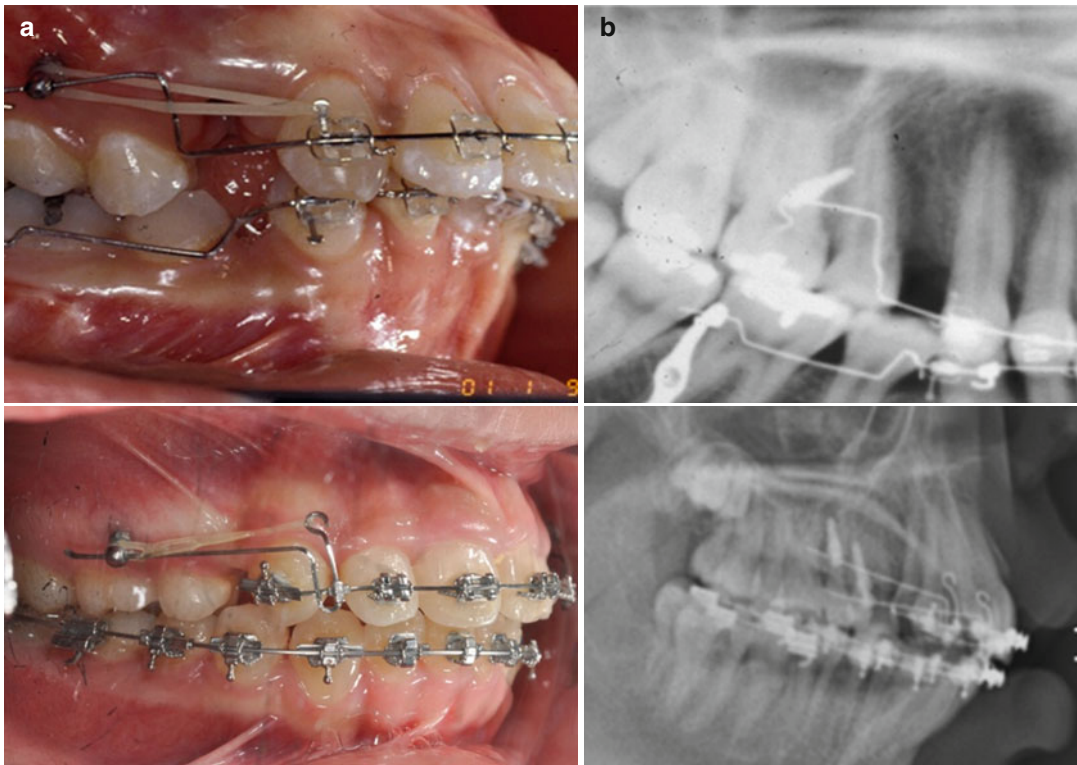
Clinical (a) and radiographic (b) pictures demonstrating the wire insertion at the head part of the C-implant
